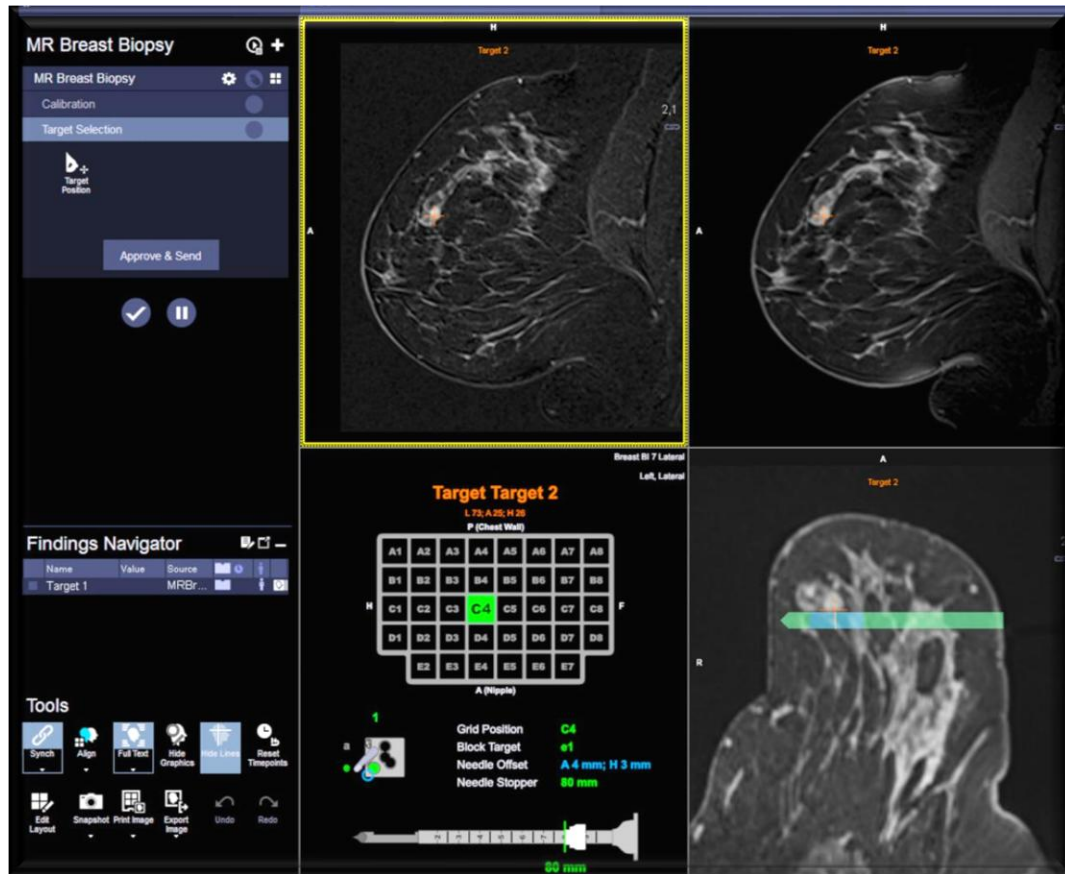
Sample MRI-guided breast biopsy planning in dedicated software application—Brevis (Siemens, Erlangen).
